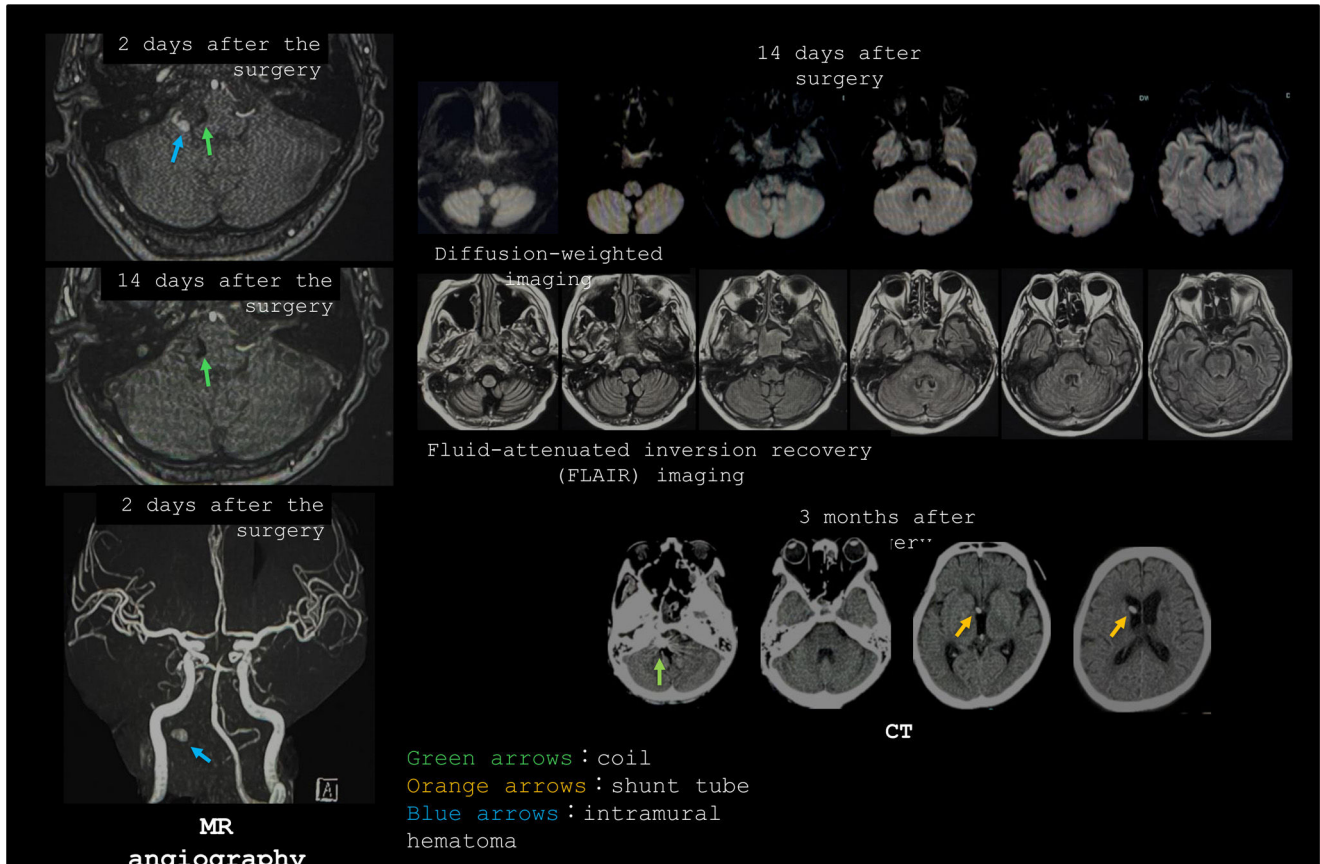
Post-operative imaging. MR angiography shows no evidence of the dissecting AICA aneurysm or the AICA itself. CT: computed tomography, MR: magnetic resonance.
